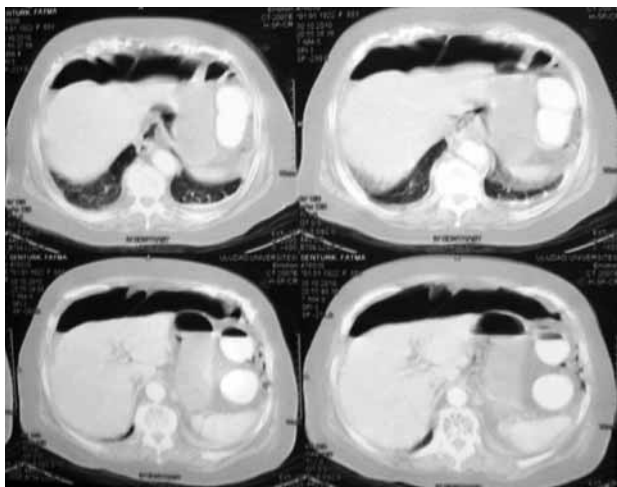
Abdominal CT of the patient showing air levels.
